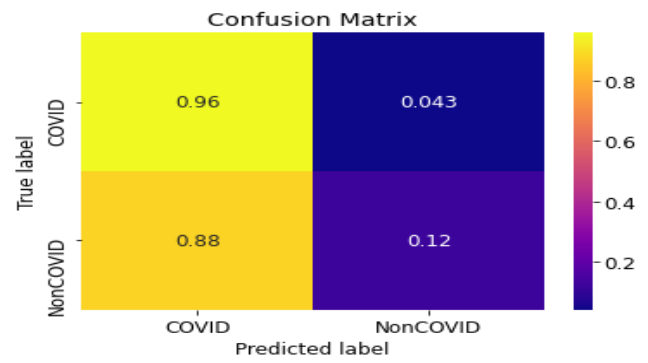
Confusion Matrix of RESNET model for CT-Scan images
